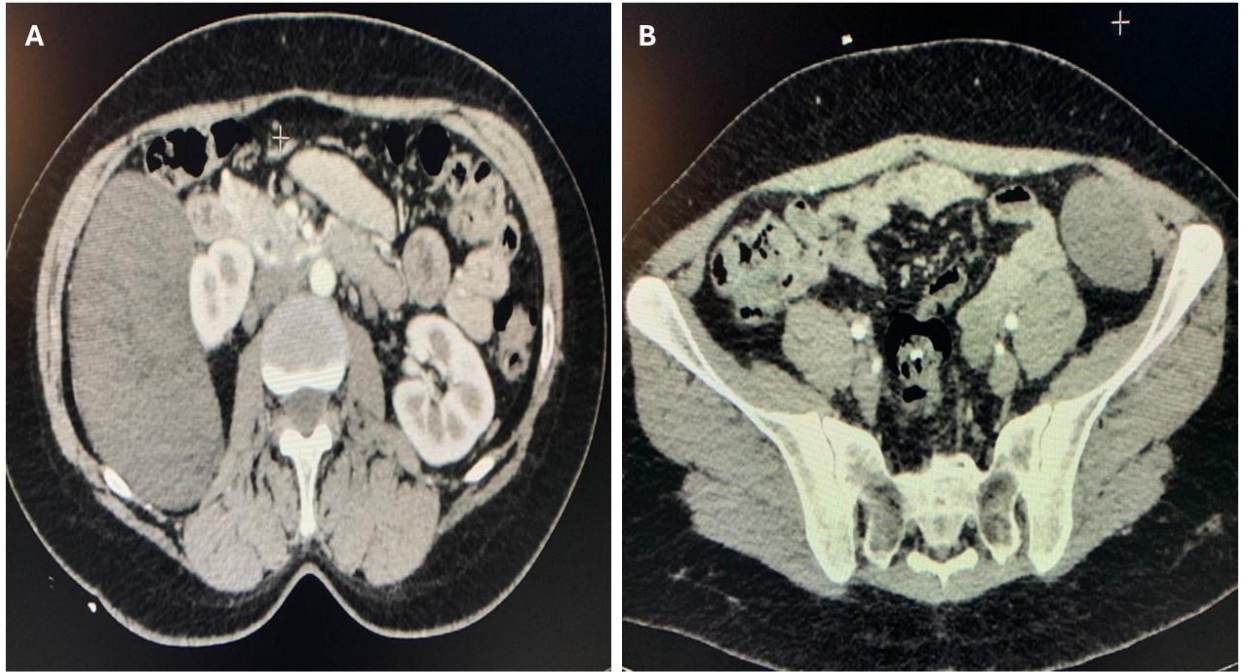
(A) Contrast-enhanced CT abdomen axial cut showing a large well-defined, faintly enhancing soft tissue mass is seen at the right side of the retroperitoneal space, postero-lateral to the right kidney. It is seen displacing and contacting the right kidney antromedially, contacting the posterior aspect of the abdominal wall laterally, and the psoas muscle posteriorly. (B): Contrast-enhanced CT abdomen axial cut showing a smaller, similar lesion is seen at the left iliac fossa, contacting the descending colon, and the abdominal wall is also noted.
